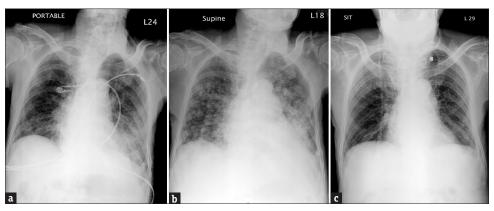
Series of chest radiographs of the patient. The chest radiograph revealed bilateral lower lung infiltration, especially the left lower lobe (a). One week later, the chest radiograph revealed left lower lung consolidation and bilateral multiple pulmonary nodules (b). After tracheostomy with intensive airway clearance, the chest radiograph revealed nearly total obliteration of the nodules and lung consolidation (c)
